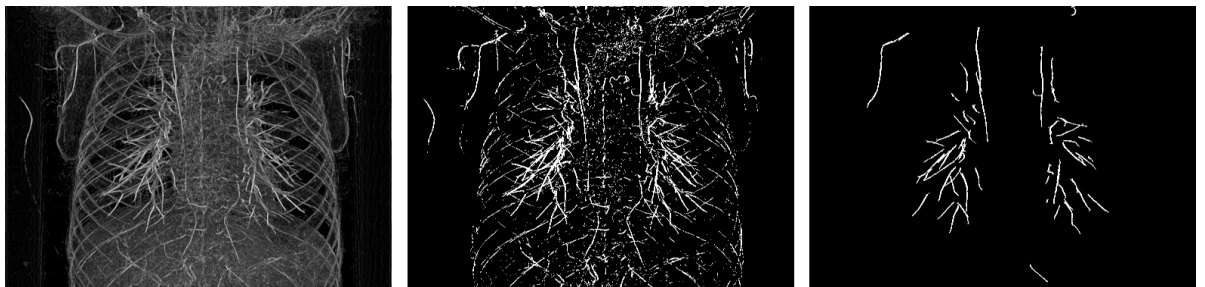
Example of normal threshold versus Hysteresis Threshold. The left image shows the result from scale space vessel detection in a CTA data-set of a human lung by the Hessian-based enhancement. The middle image presents the result after applying a regular threshold operation, whereas the right image uses HT and is far less noisy, due to the adjustable two threshold values. Furthermore, it is noteworthy to mention that less noise leads to smoother centerlines. (Images created using the AngioVis Toolbox)*
